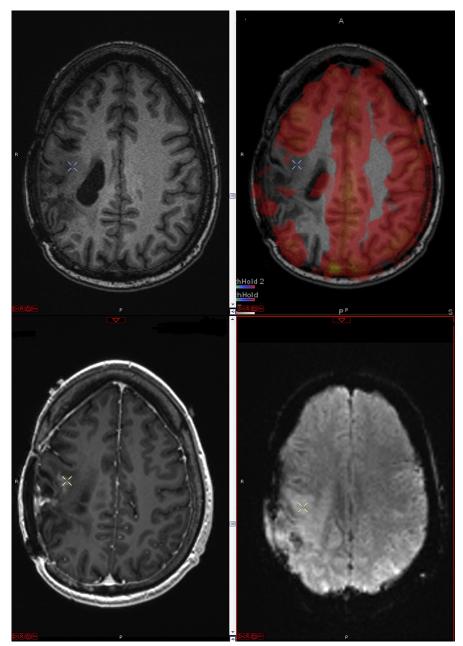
Demonstration of NVU in a patient with a right parietal lesion, previously resected, with recurrent enhancement and consideration of reresection. The crosshairs localize to the enhancing lesion of interest. The bottom right raw echo-planar images show no significant susceptibility in this region, despite overlying craniotomy. The top right breath-hold cerebrovascular reactivity maps overlaid onto T1-weighted images show absence of cerebrovascular reactivity in the location of the lesion and posterior to it. (*Top left*) Precontrast T1; (*bottom left*) postcontrast T1.
